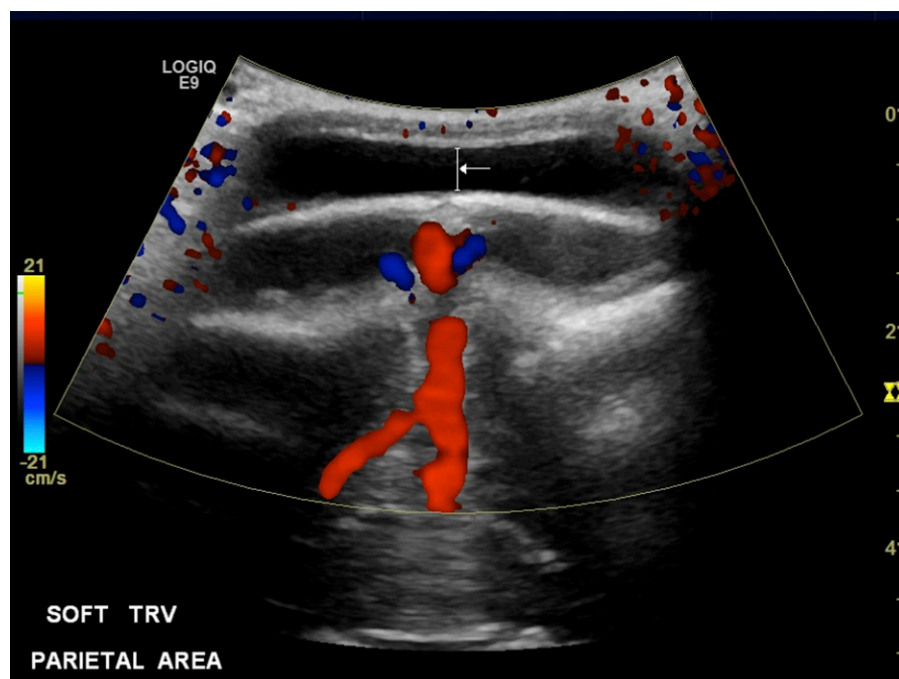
Head ultrasound scan, with the arrow demonstrating a 4.3×2.2×0.5 cm anechoic fluid collection within the scalp in the right parietal region.
